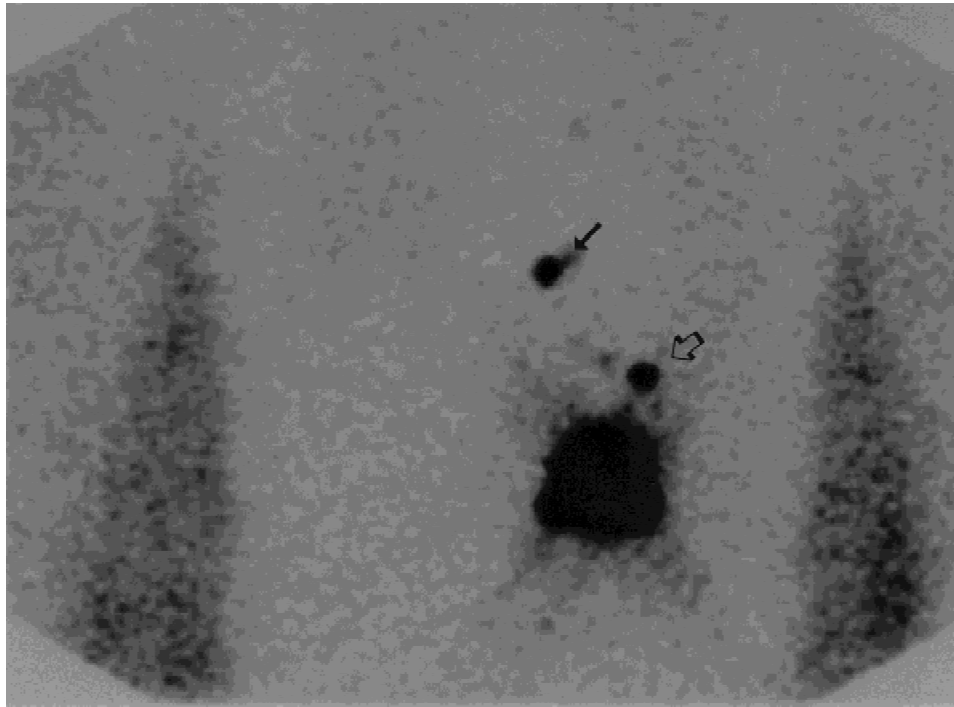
35-year-old white male with a 2.0 mm malignant melanoma excised from the left upper abdomen. Clinically the predicted cutaneous lymphatic flow would be to the left axilla. With preoperative lymphoscintigraphy, the left axilla is found not to be at risk for metastatic disease, but lymphatic flow was noted to an intransit node in the left upper abdomen within 5 cm of the primary site and to a lower internal mammary node (closed arrow). With the use of the Neoprobe for intraoperative mapping, both nodes (open arrow) were harvested. Pathology was negative.
